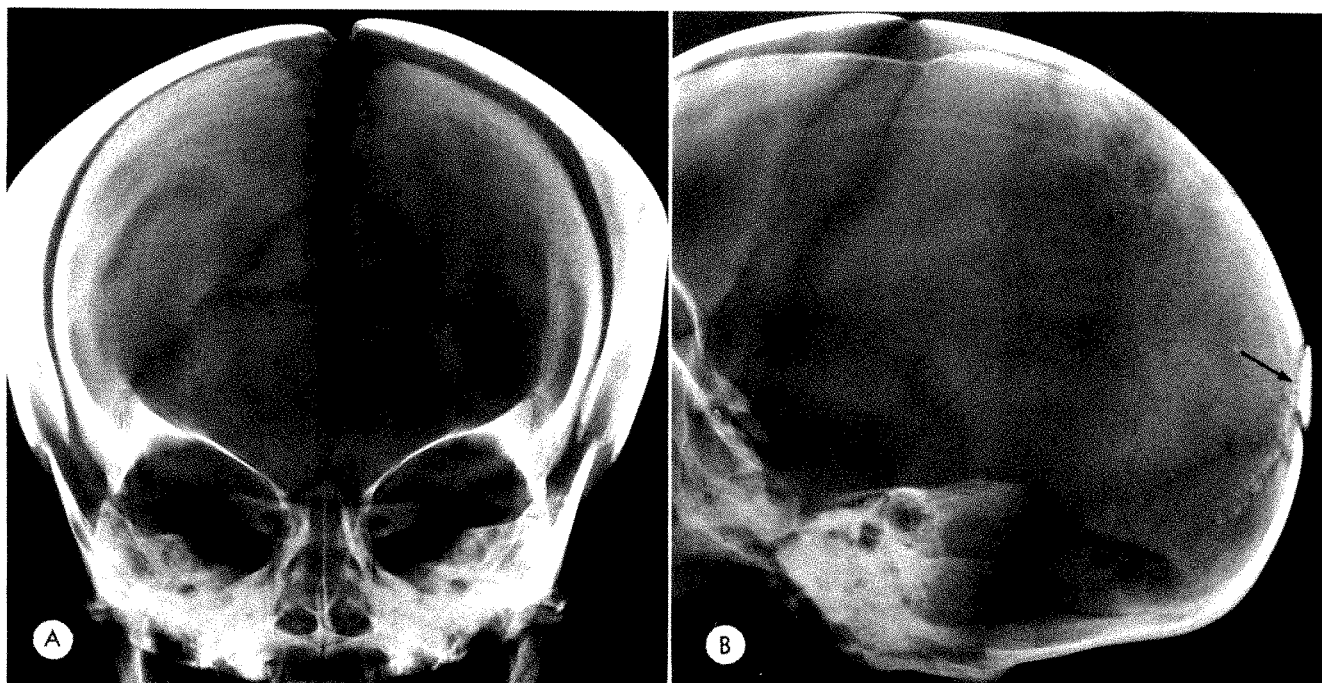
Frontal (A) and lateral (B) radiographs of skull of stillborn full term infant demonstrating classical triangular os incae (ip). Note sclerotic appearance in lateral projection (arrow).
